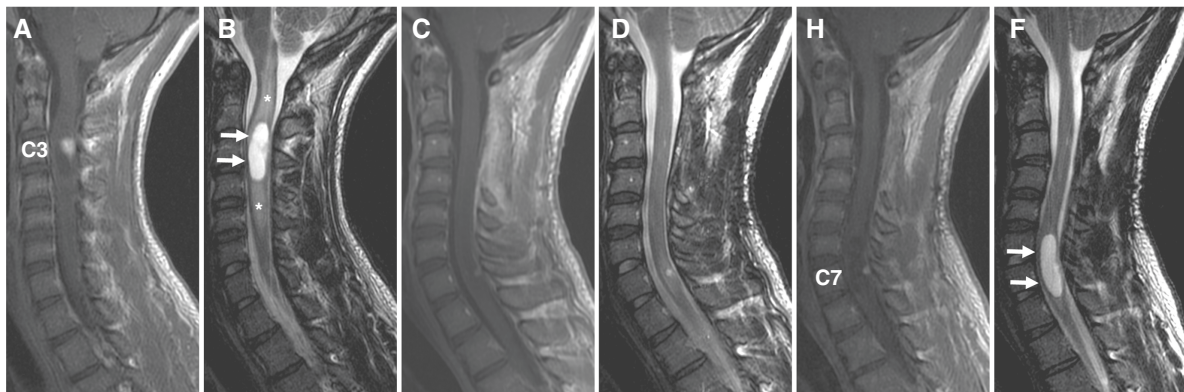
Sagittal T1- and T2-weighted magnetic resonance (MR) imaging of the cervical spine in a von Hippel-Lindau disease patient demonstrating an intramedullary hemangioblastoma. Preoperative contrast-enhanced imaging (A) and T2-weighted imaging (B) show a hemangioblastoma with associated syrinx (arrows) and spinal cord edema (asterisks). Laminectomies were performed for access. Postoperative imaging obtained at 7 months follow-up confirmed complete resection (C) and demonstrated syrinx and edema reduction (D). Twenty month follow-up (E and F) showed progression of another hemangioblastoma at C-7 with syrinx development (arrows). *Figure adapted from Mehta et al.⁸
